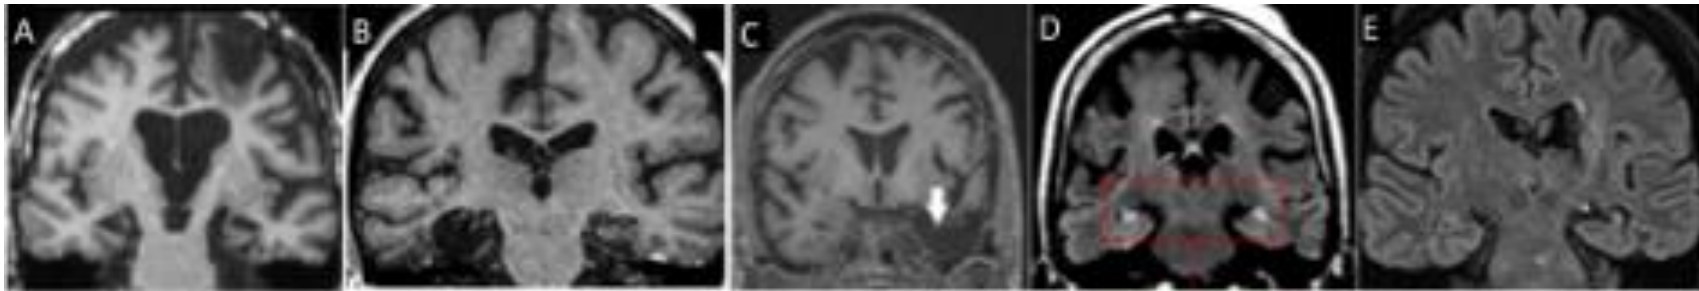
Coronal T1 MRI slices of damage for (A) K.C., (B) D.A., (C) L.D., (D), B.L., and (E) S.N. Images are presented according to radiological convention (right hemisphere is presented on left side of image). D.G. could not be scanned because of an implantable cardioverter defibrillator.
